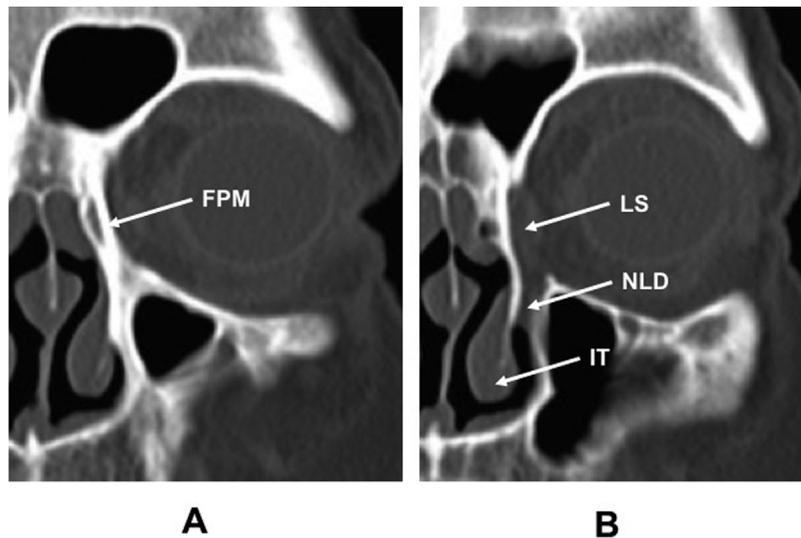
Coronal CT scans of lacrimal sac region.
